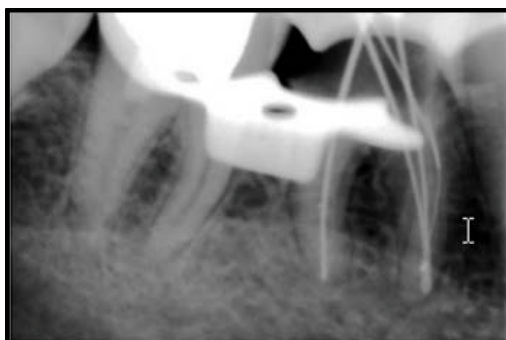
Working length radiograph demonstrated three mesial canals.
